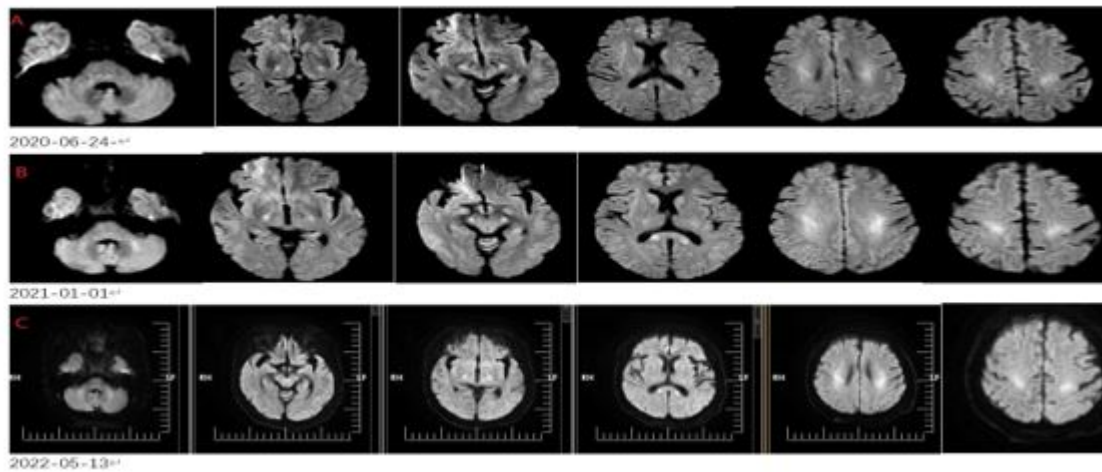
DWI findings in the past two years. A) Diffusion-weighted imaging MRI of June 24, 2020 showing symmetrical bilateral hypertension in the cerebral peduncle, posterior limbs of the internal capsules, corpus callosum, corona radiata and frontal lobes. B) Diffusion-weighted imaging MRI of January 1, 2021 showing the lesion above is still exist with additional of the cerebellar peduncle (outstanding in the left). C) Diffusion-weighted imaging MRI of May 13, 2022 showing it still exists, and the lesion in the cerebellar peduncle became symmetrical.
